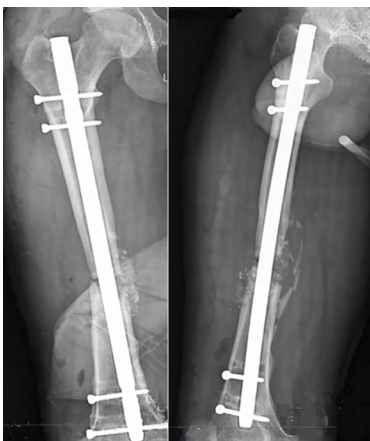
Post-operative X-ray. Anteroposterior and lateral view
